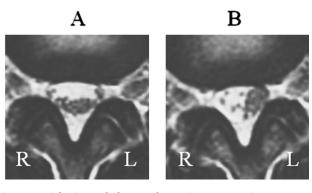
Axial view of the cauda equina. Magnetic resonance imaging (T2 weighted, spin echo, TR 2000/TE, 100 ms) at L2–3 level in the same subject were obtained in the supine position (A) and in the left lateral decubitus position (B). After changing position, the cauda equina markedly moved to the left side of the subarachnoid space. L = left; R = right.
